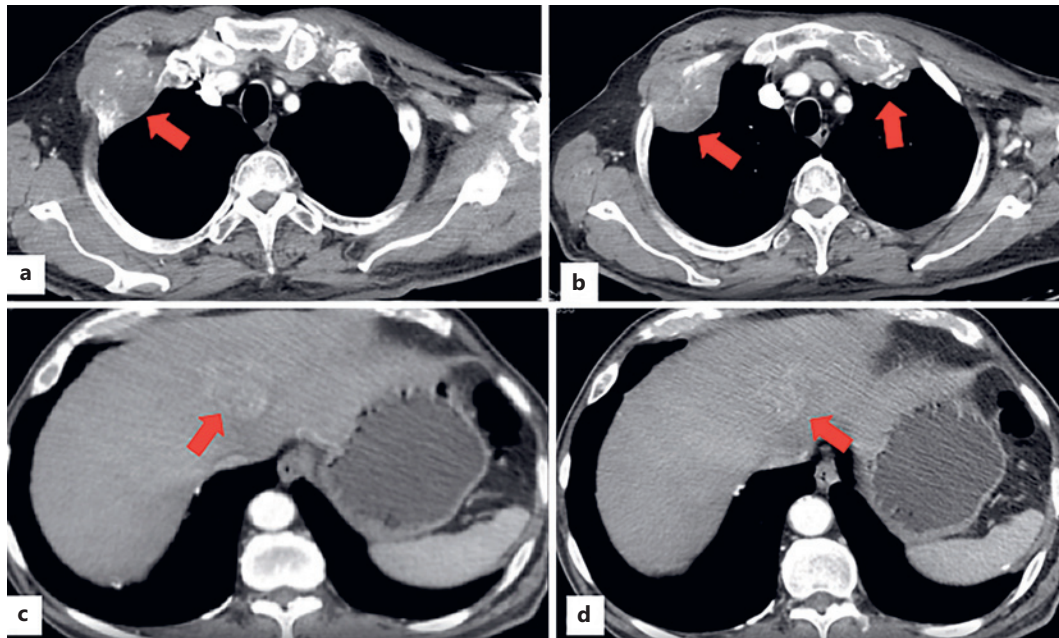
Thorax and abdomen computed tomography with contrast revealed bone metastatic lesions at the level of the 2nd right rib, 1st left rib, and sixth and twelfth thoracic vertebrae (a, b) and a hepatic lesion with arterial enhancement and late venous washout (c, d).
